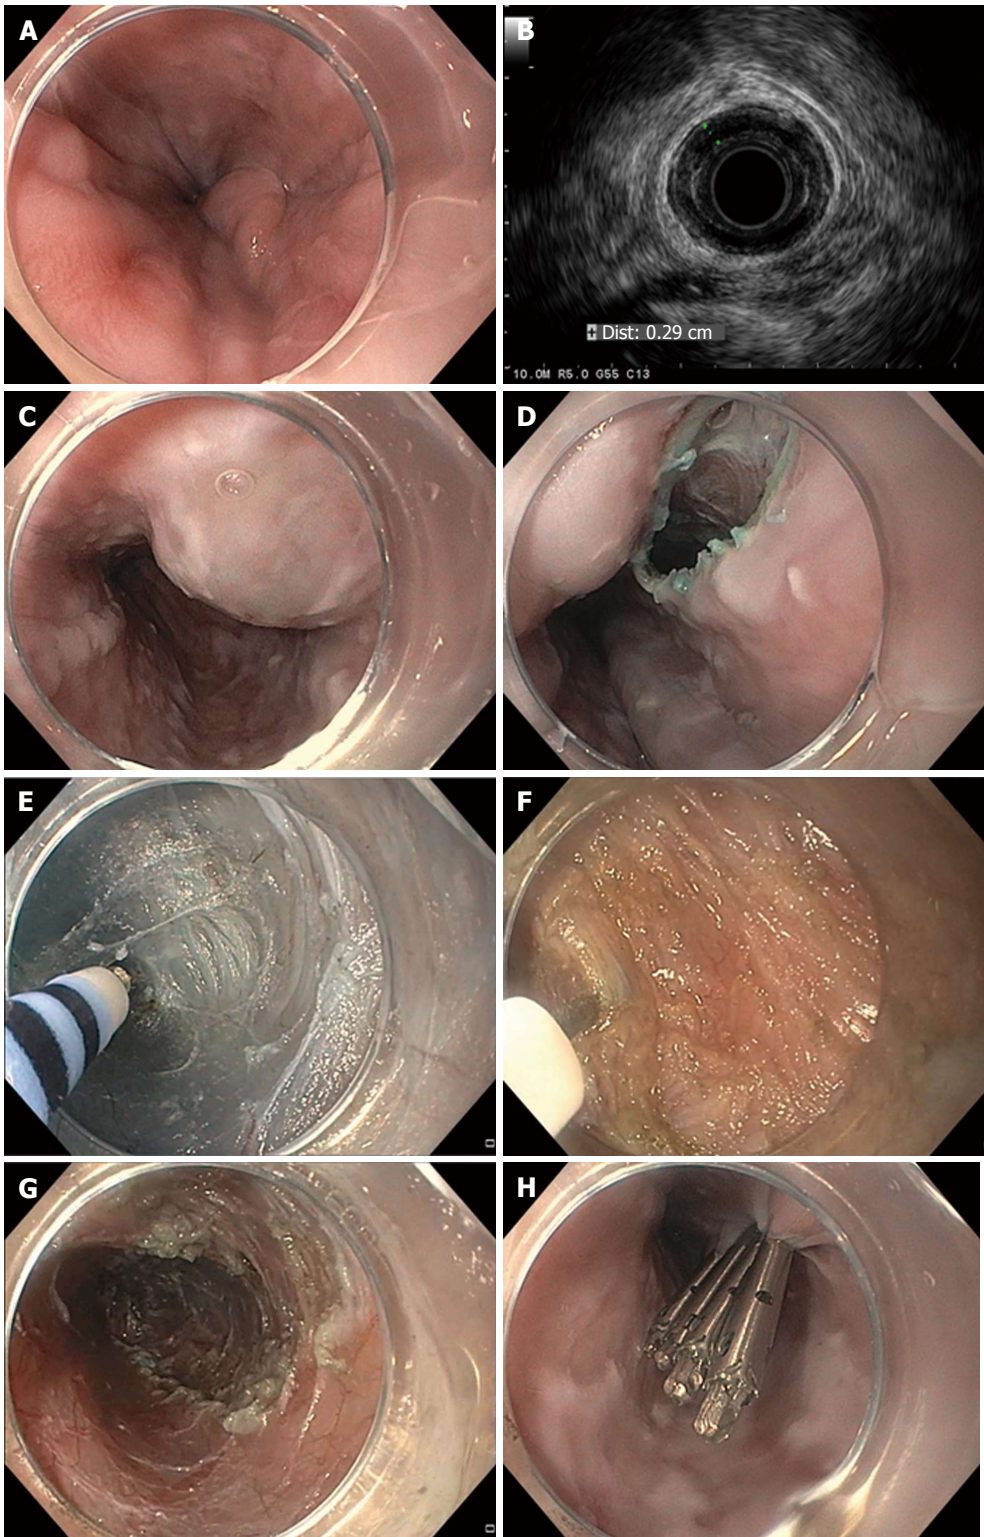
Per oral endoscopic myotomy in a patient with achalasia. A 56-year-old man with type II achalasia and a history of chronic alcohol use underwent attempted laparoscopic Heller myotomy. Upon retraction of the liver during surgery, large gastroesophageal varices were noted to arise and the surgery was aborted. The patient was exhorted to stop drinking alcohol. Doppler ultrasonography and magnetic resonance imaging with arterial and venous phase imaging did not show any significant gastroesophageal varices or obvious portal hypertension. Per oral endoscopic myotomy (POEM) was performed. Endoscopic views in the distal esophagus found some enlarged veins but no high-grade esophageal or gastric varices (A); Radial endosonography found a thickened deep circular muscle layer measuring 2.9 mm, which is commonly found in patients with achalasia, but no obvious esophageal varices were noted (B); A mucosal weal was created by injecting saline tinted with indigo carmine (C); and a mucosal entry incision was made (D); Submucosal dissection was carried out with sequential injection and electrosurgical dissection (E) using a T-type Hybrid knife in conjunction with an ERBEJET 2 and a VIO 300 D generator set at EndoCut Q 3-2-1 (ERBE, Marietta, GA, United States). Dissection of the circular layer of the muscularis propria was performed using the T-type Hybrid knife (F); After completion of the 7-cm-long myotomy in the distal esophagus that was carried out an additional 2 cm into the gastric cardia (G); the mucosal entry site was closed by using endoclips (H). The patient did well without any intra- or post-procedural bleeding. At clinic follow-up 2 mo later, the patient reported complete resolution of his symptoms of dysphagia and weight gain of 14 lbs.
